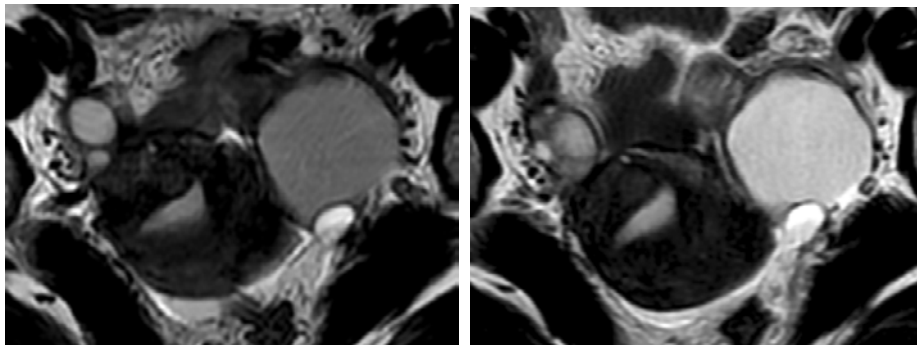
T2-weighted images of a left endometrial cyst at 3T (left) and at 1.5T (right). The shading sign was demonstrated at 3T but not at 1.5T.
